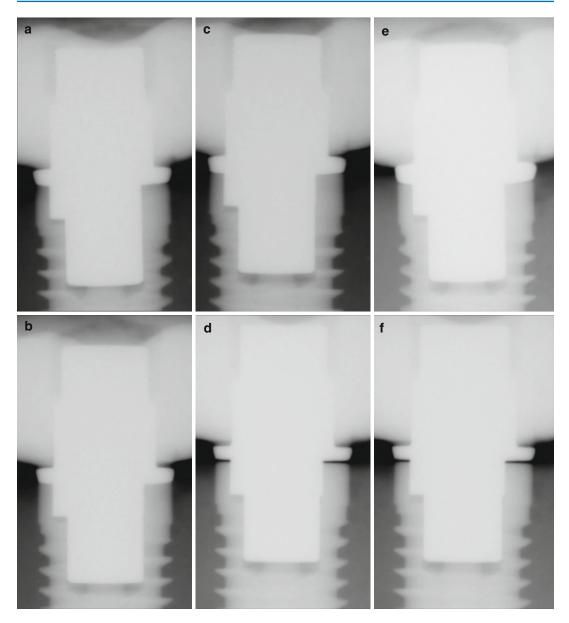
Examples of radiographs with different gap dimension, from 0 to 100 μ m, typical of those produced in the study with and without the PIXRL device. (a) 0 μ m
